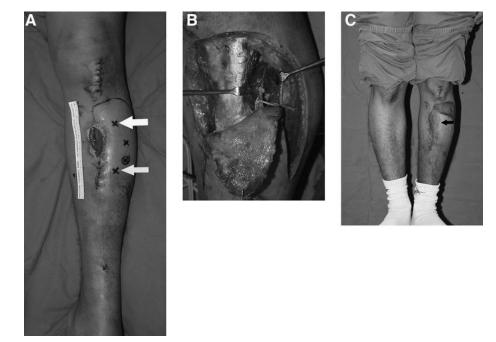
Patient of case 1. A, A perforator-sparing transposition flap was planned for coverage of a middle-third defect of the leg. Preoperative Doppler assessment identified the location of cutaneous perforators. The top arrow indicates the perforator to be mobilized and the bottom arrow indicates the perforator at the base of the flap to be preserved. B, Intramuscular dissection of the musculocutaneous perforator to its origin at the anterior tibial artery. C, Patient at 6-month followup. Doppler assessment confirmed the patency of the preserved perforator (arrow).
